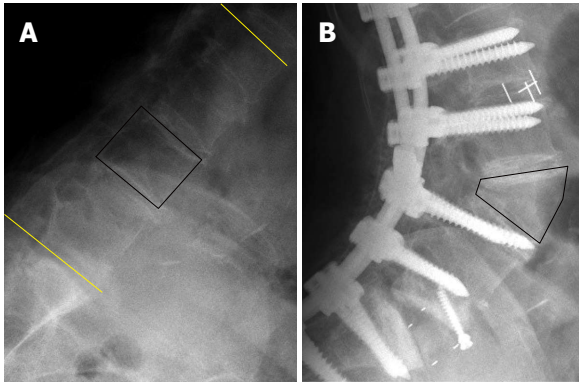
Pre- and post-operative lateral plain radiographs of a 70-year-old woman who underwent pedicle subtraction osteotomy at the L3 vertebra. Kyphotic lumbar spine (A) and hyperlordotic lumbar spine after pedicle subtraction osteotomy (B). Note that the length of the anterior vertebral cortex remains unchanged even after the shortening of the middle and posterior spinal columns.
